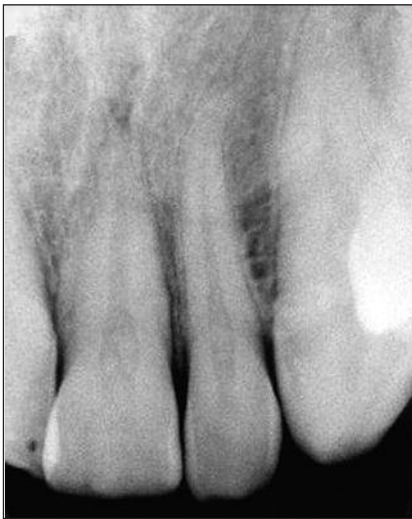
The radiographic image of the other side after trauma.
